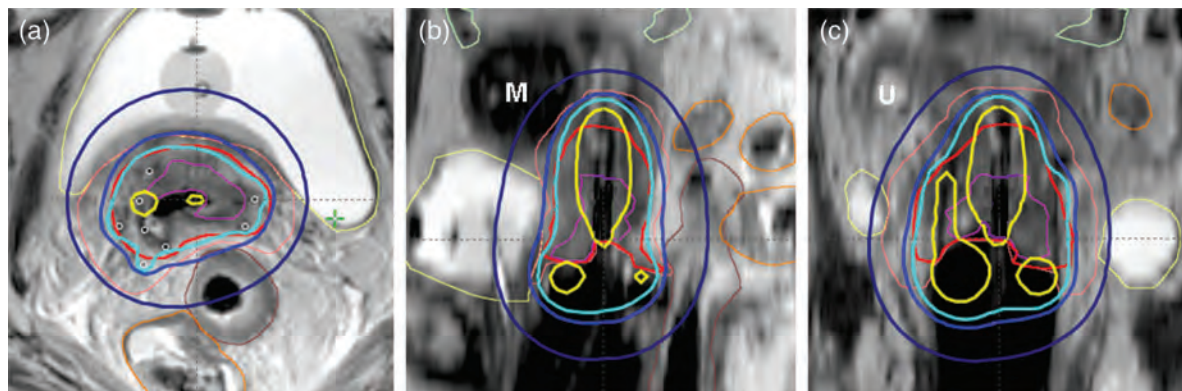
Targets, organs at risk, and dose distribution for PDR BT₁ is shown in a para-transverse (a), para-coronal (b), and sagittal plane (c) just above the ring on a T2-weighted MRI with the brachytherapy applicator *in situ*. The fibromyoma (M) in the uterus is seen on (b) and the hydroureter (U) is seen on the right in (c). The positions of the needles are marked with white circles in (a). The brachytherapy target contours are indicated with magenta (GTV_{res}), red (CTV_{HR}), and pink (CTV_{IR}). The outer contours of organs at risk are indicated with yellow (bladder), brown (rectum), orange (sigmoid), and light green (bowel). The iso-doses shown are for 33 Gy (200 %) (yellow), 16.5 Gy (100 %) (cyan), 12.7 Gy (blue), and 6.1 Gy (dark blue), corresponding to the volumes treated to a total EQD2₁₀ (EBRT and brachytherapy) of 140, 85, 75, and 60 Gy, respectively.
